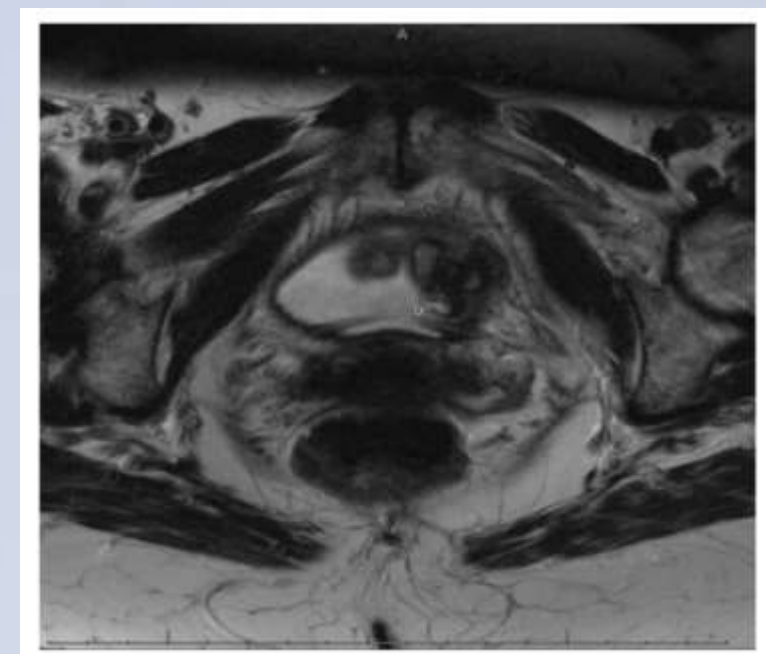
Axial view MRI demonstrating erosion of MPQ into the left bladder neck/bladder
